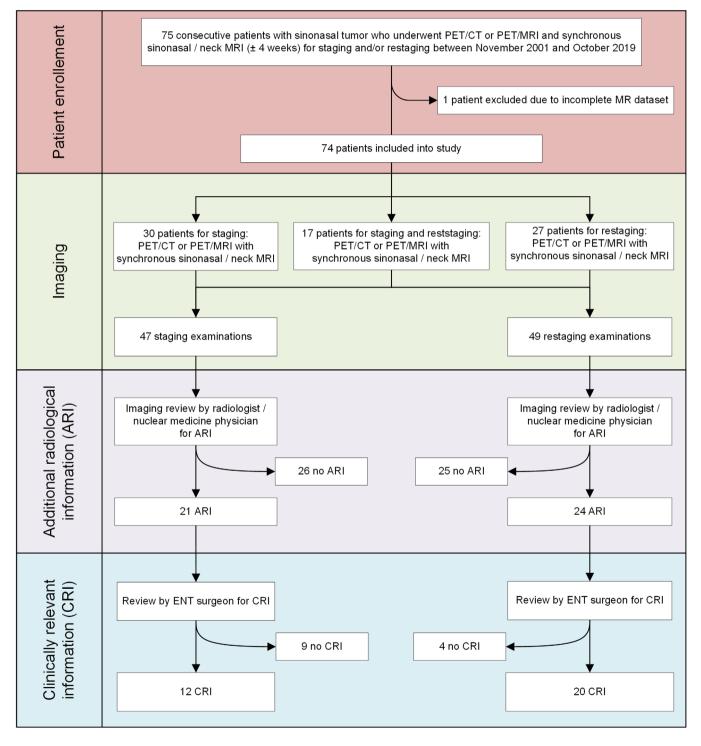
Details on patient enrollment and study design. ARI, additional radiological information; CRI, clinically relevant information; MRI, magnetic resonance imaging; PET/MRI, positron emission tomography/magnetic resonance imaging; PET/CT, positron emission tomography/computed tomography [Color figure can be viewed at wileyonlinelibrary.com]
